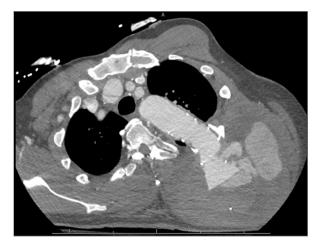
Axial cardiac computed tomographic angiogram performed 1 year postoperatively demonstrates a type IIIB endoleak with complete stent graft–strut disruption and contained rupture into the posterior chest wall musculature.
